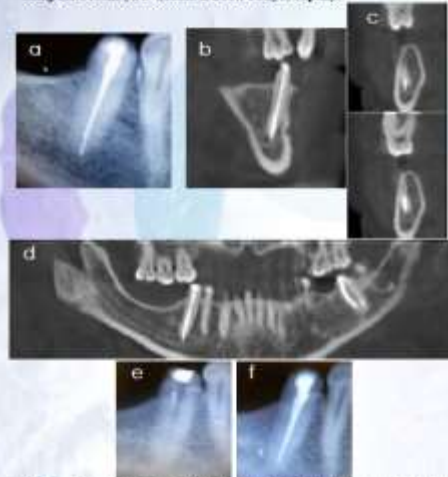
a- previous root canal treatment, b,c,d-CBCT examination of tooth 43 revealing gutta-percha in a relation with mental nerve, e-removal of extended gutta-percha, f-final root canal retreatment.
